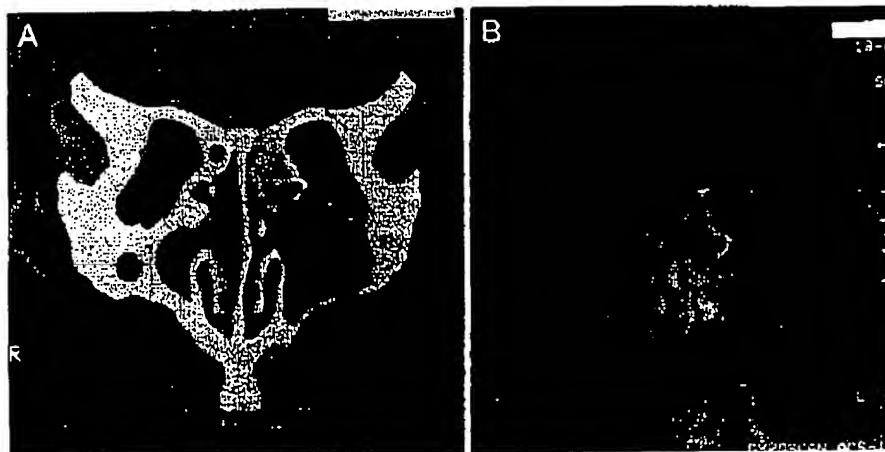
Comparison of (A) CT scan and (B) T₁-weighted MRI of the same patient with allergic fungal sinusitis. Note that MRI (right) results in a decrease of signal intensity within the involved paranasal sinuses filled with allergic fungal mucin. (Reprinted with permission from Manning et al.²⁶)
